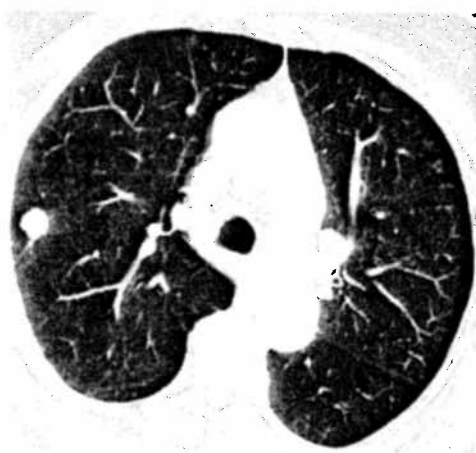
CT After Six Months of Treatment
